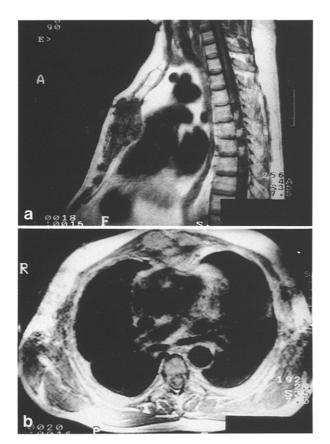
a, b. Pre-operative MRI imaging to show the mass in the sternum
